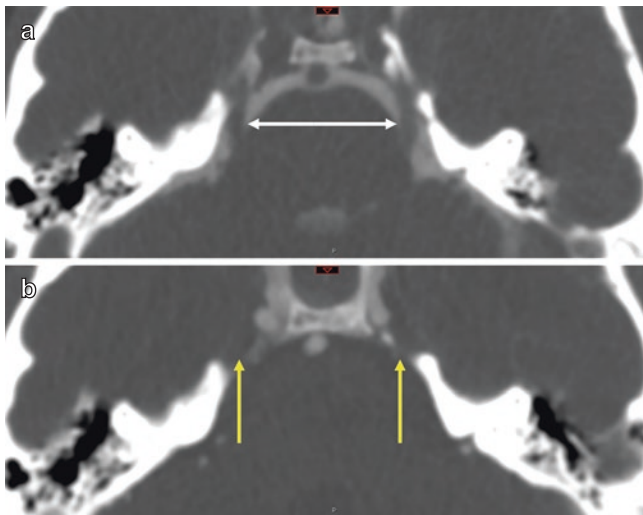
CT landmarks of trigeminal nerve. CT cisternogram (a) and contrast-enhanced CT (b) demonstrating the trigeminal impression on the petrous ridge (yellow arrow) and the pars triangularis of the cisternal segment CN V several millimeters proximally (white arrow)
